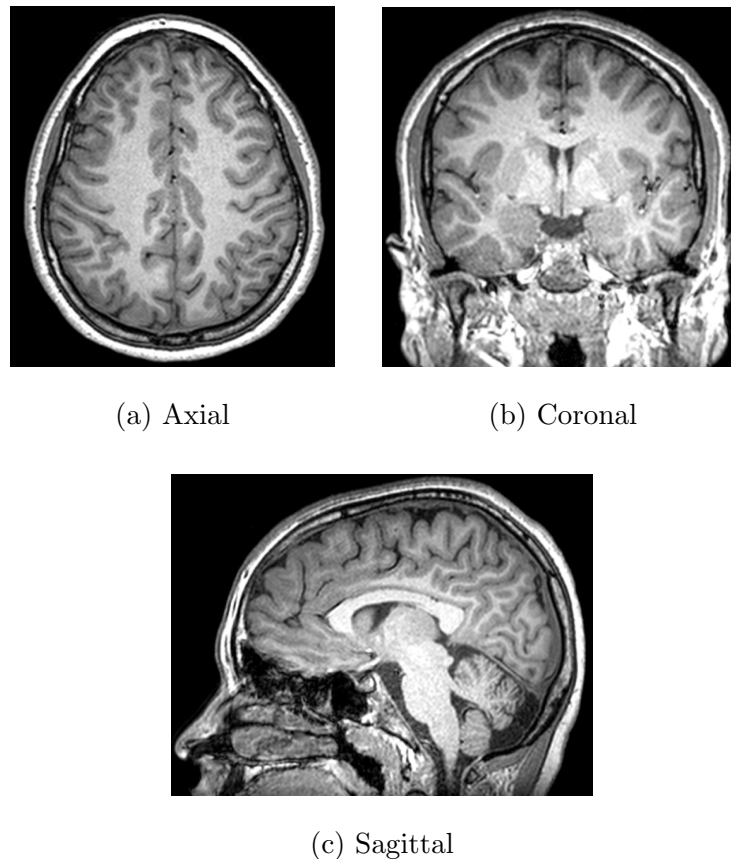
Sample T1-weighted acquisition. (a) displays the axial slice, (b) the coronal slice and (c) the sagittal slice of the T1 acquisition of subject NL004.
